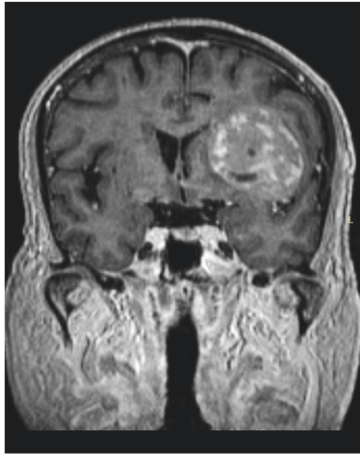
Coronal T1-weighted postcontrast MR images of a patient with HGG used for RTP.
